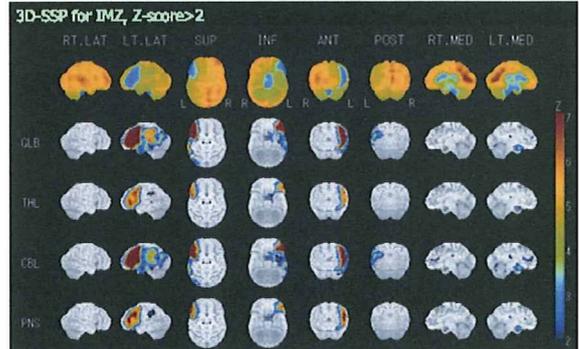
図5の症例の IMZ-SPECT 3D-SSP (Z-score) 解析 (上段より、IMZ の分布、全脳・視床・小脳・橋で正規化した Z-score 画像)
